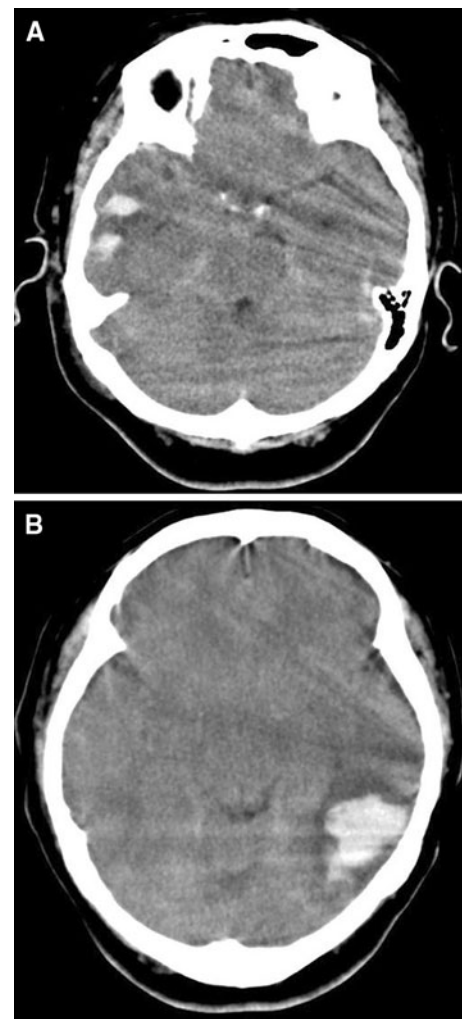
Emergency CT of the brain showed a subdural hematoma in the right temporal area, an intraparenchymal hemorrhage in the left occipital lobe, a subarachnoid hemorrhage, and brain swelling
